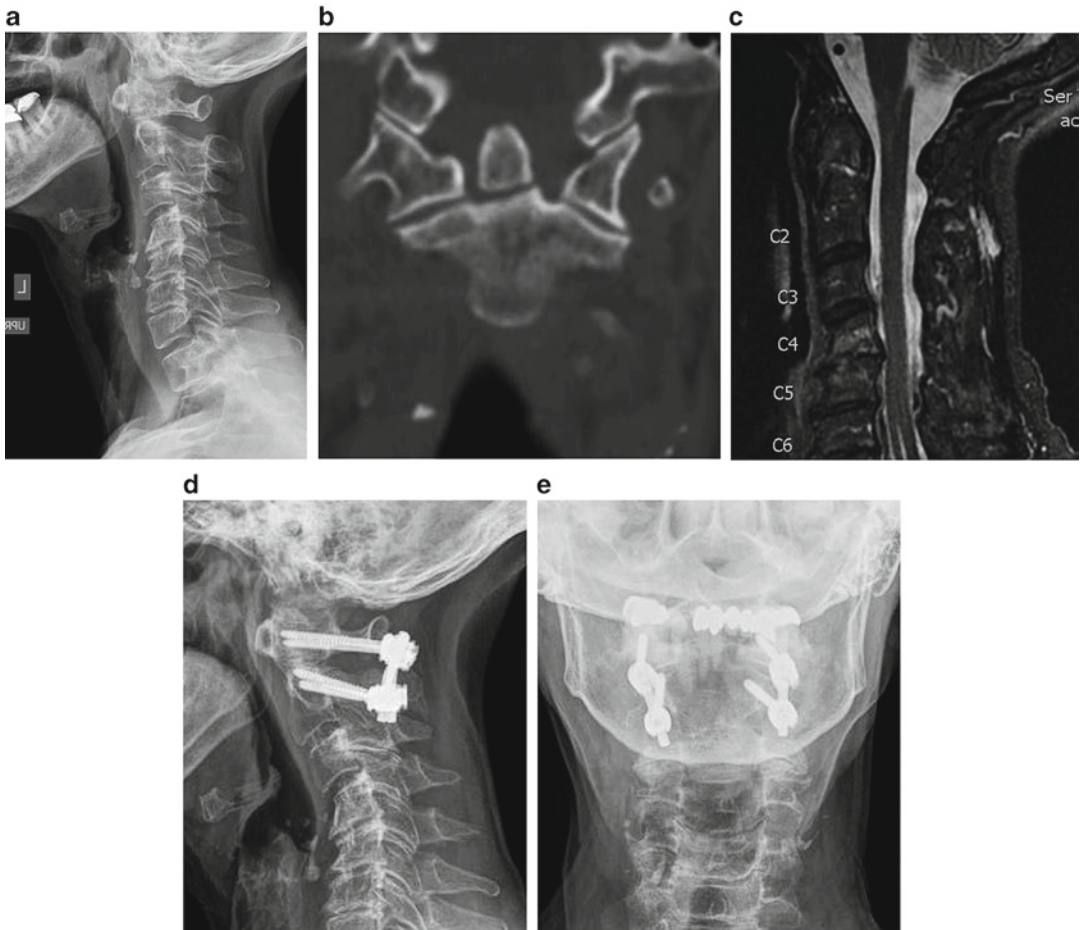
(a) Initial lateral radiograph of 66-year-old female with non-displaced type II dens fracture. (b) Coronal CT shows nonunion of dens fracture. (c) Sagittal T2-weighted MRI demonstrates increased signal in nonunion of dens fracture. No spinal cord compression is
